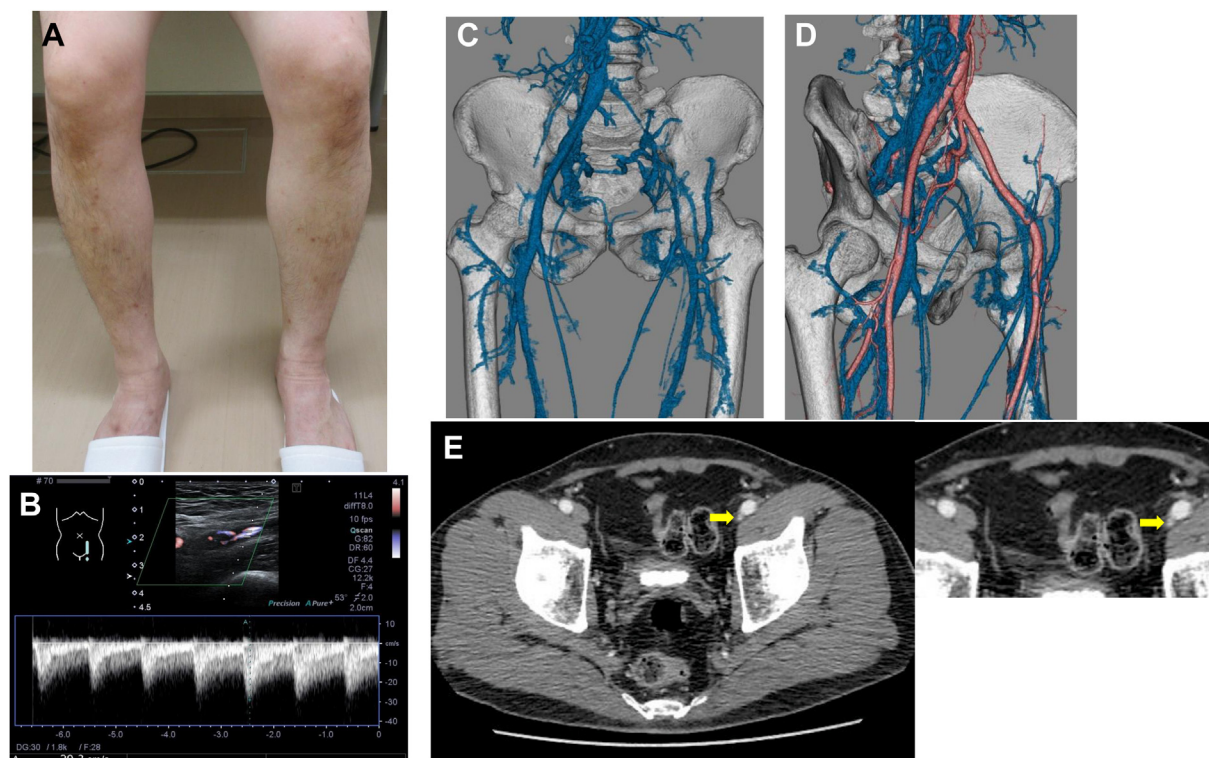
Clinical data of case 3. A, No signs of swelling or dermatitis symptoms in the left lower extremity. B, Duplex ultrasound examination showed an arterialized waveform at the distal part of the occluded left external iliac vein (EIV). C, Computed tomography (CT) angiography three-dimensional (3D) reconstruction (venous phase). Occlusion of the left common iliac vein (CIV) and EIV with moderately developed collateral vessels. D, CT angiography 3D reconstruction (arterial and venous phase). The exact locations of the arteriovenous fistula were not identified. E, Contrast-enhanced CT showing early opacification (yellow arrow) of the distal part of the occluded left EIV (with its enlarged view).
